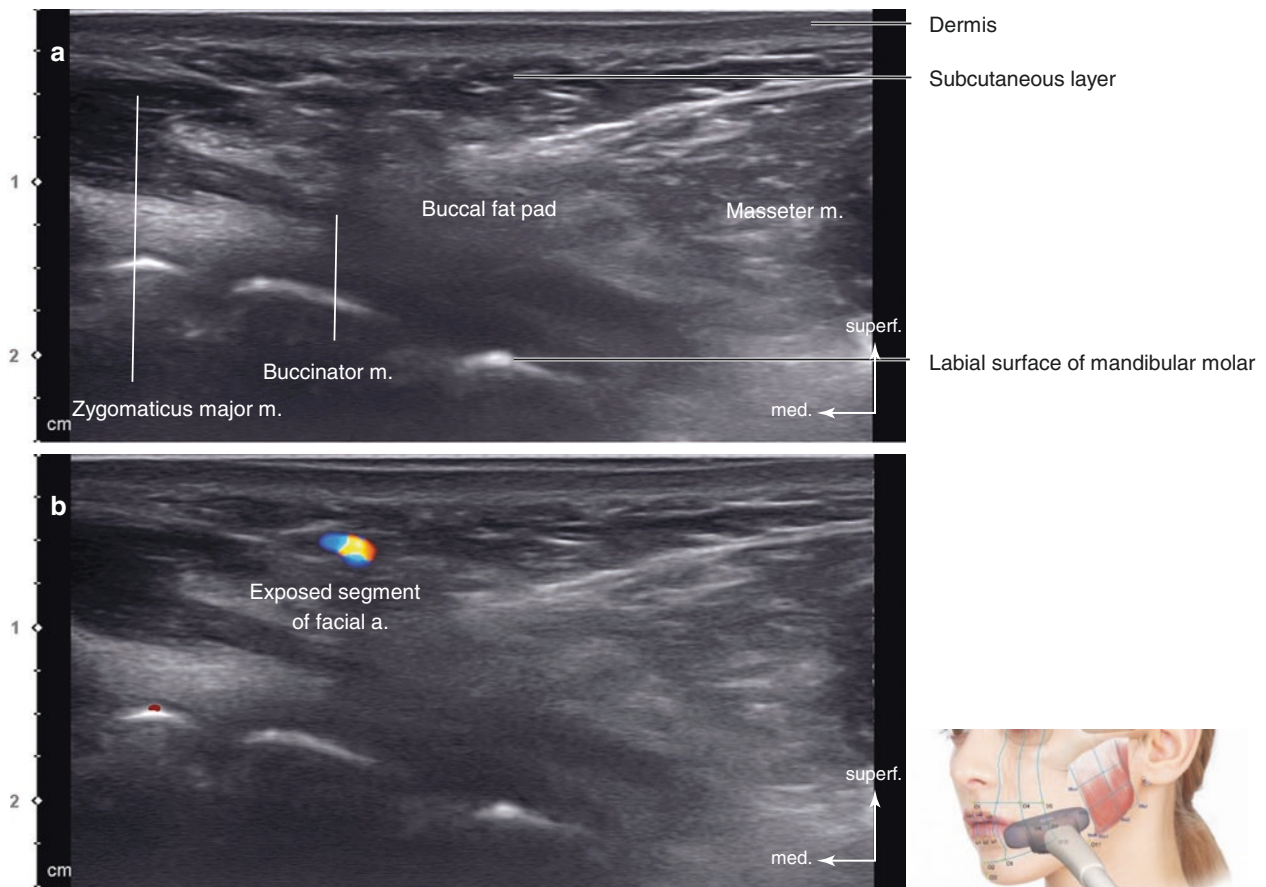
Ultrasonography of the intersection point of TL7 and PL3 (O7). (a) B mode (transverse view, 15 MHz by linear transducer) and (b) Doppler mode (transverse view, 15 MHz by linear transducer). (Published with kind permission of © Hee-Jin Kim 2020. All Rights Reserved)
